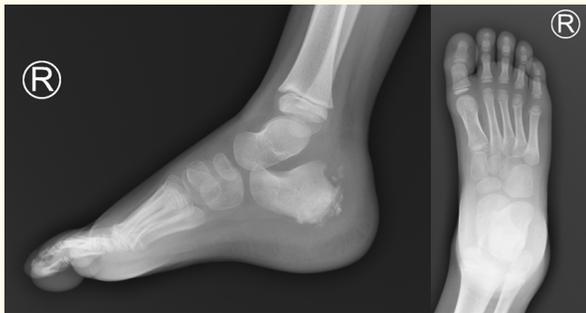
Lateral (A) and anteroposterior (B) non-weight-bearing radiographs of the right foot demonstrating a lytic and destructive process of the posterior aspect of the calcaneus.
